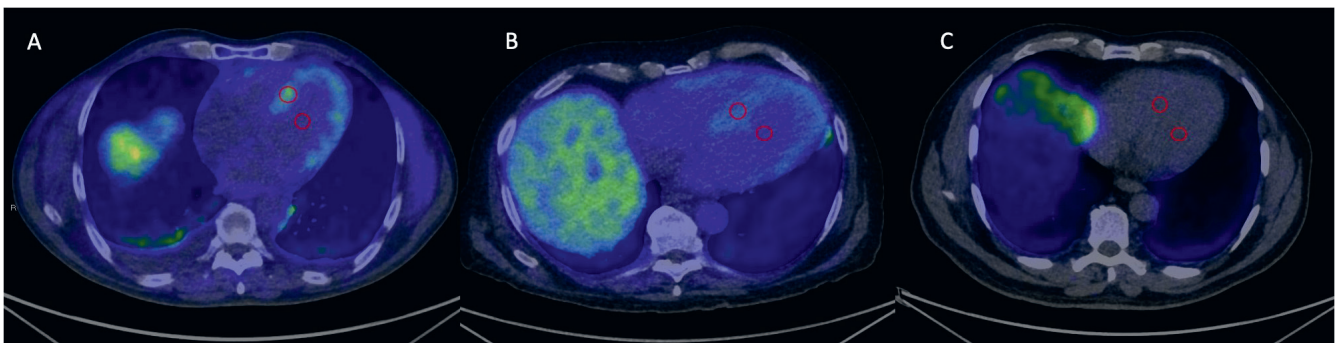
^{11}C -labeled Pittsburgh compound-B (^{11}C -PiB) positron emission tomography/computed tomography (PET/CT)
